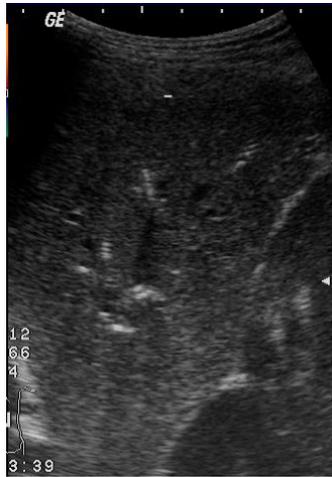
Abscess with persistent fever. Ultrasound guided aspiration surprisingly showed tuberculous bacilli.
